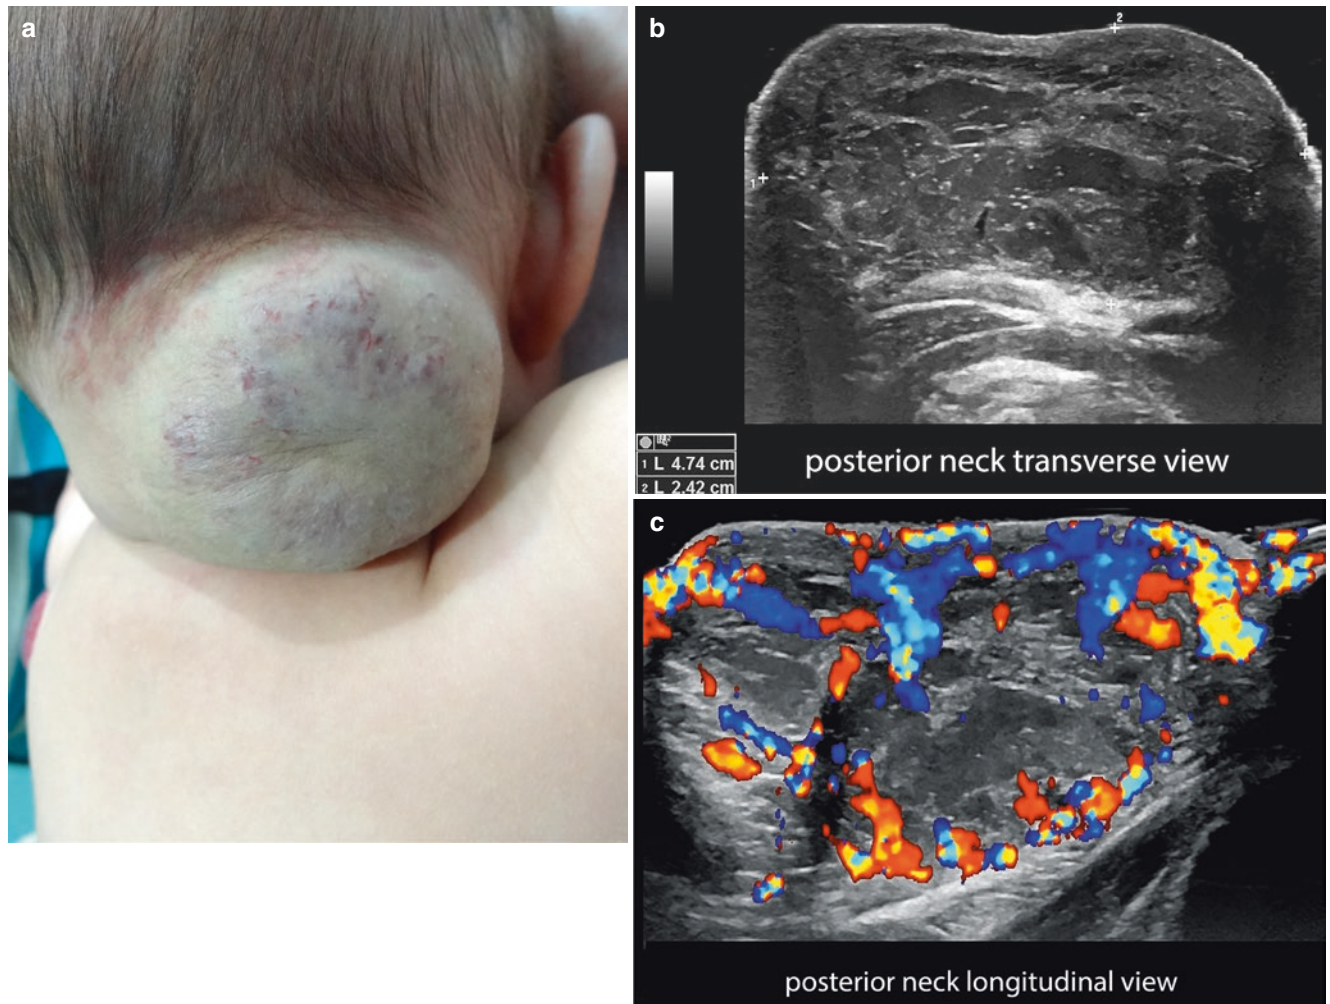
Non-involuting congenital hemangioma (NICH) in a 3-month-old child. (a) Clinical image (posterior neck). (b and c) Greyscale and color Doppler ultrasound (b, transverse view; c, longitudinal view) shows 4.74-cm (transverse) \times 2.4-cm (thickness) hypoechoic
